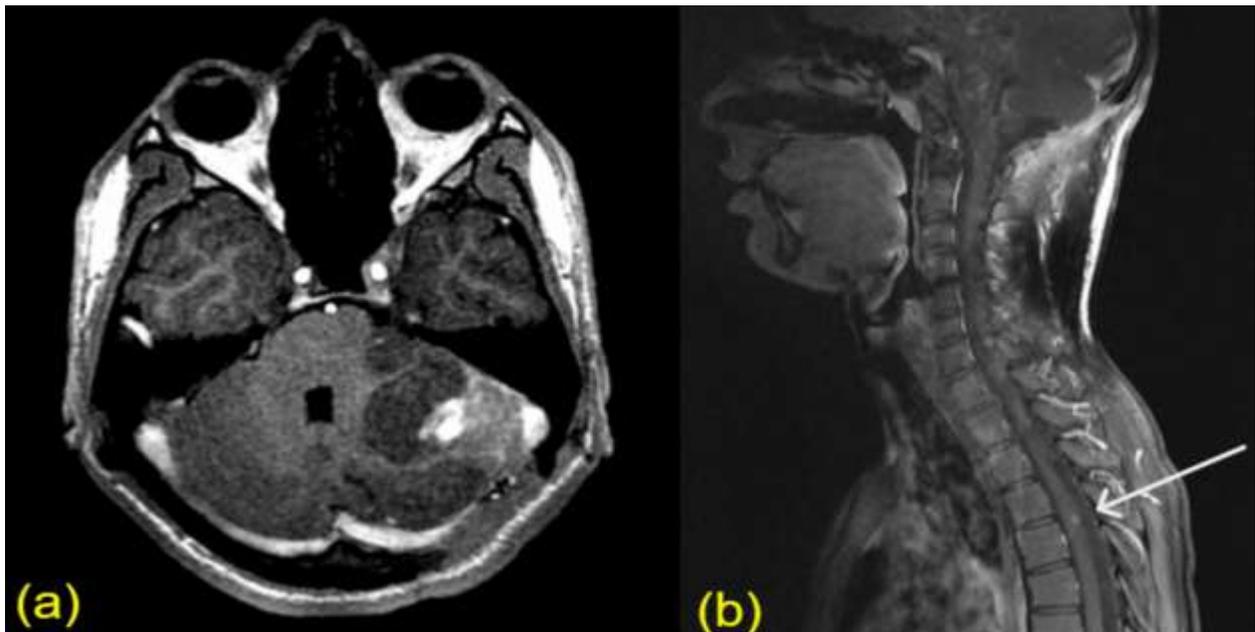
(a) Axial contrast-enhanced MRI of the brain demonstrating a left cerebellar tentorial mass and (b) Sagittal cranio-cervico-thoracic MRI demonstrating an intradural extramedullary drop metastasis at the T5 vertebral level (arrow).
